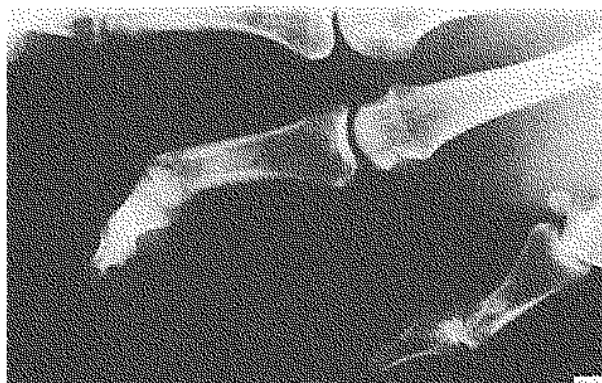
Radiograph of case 2.
